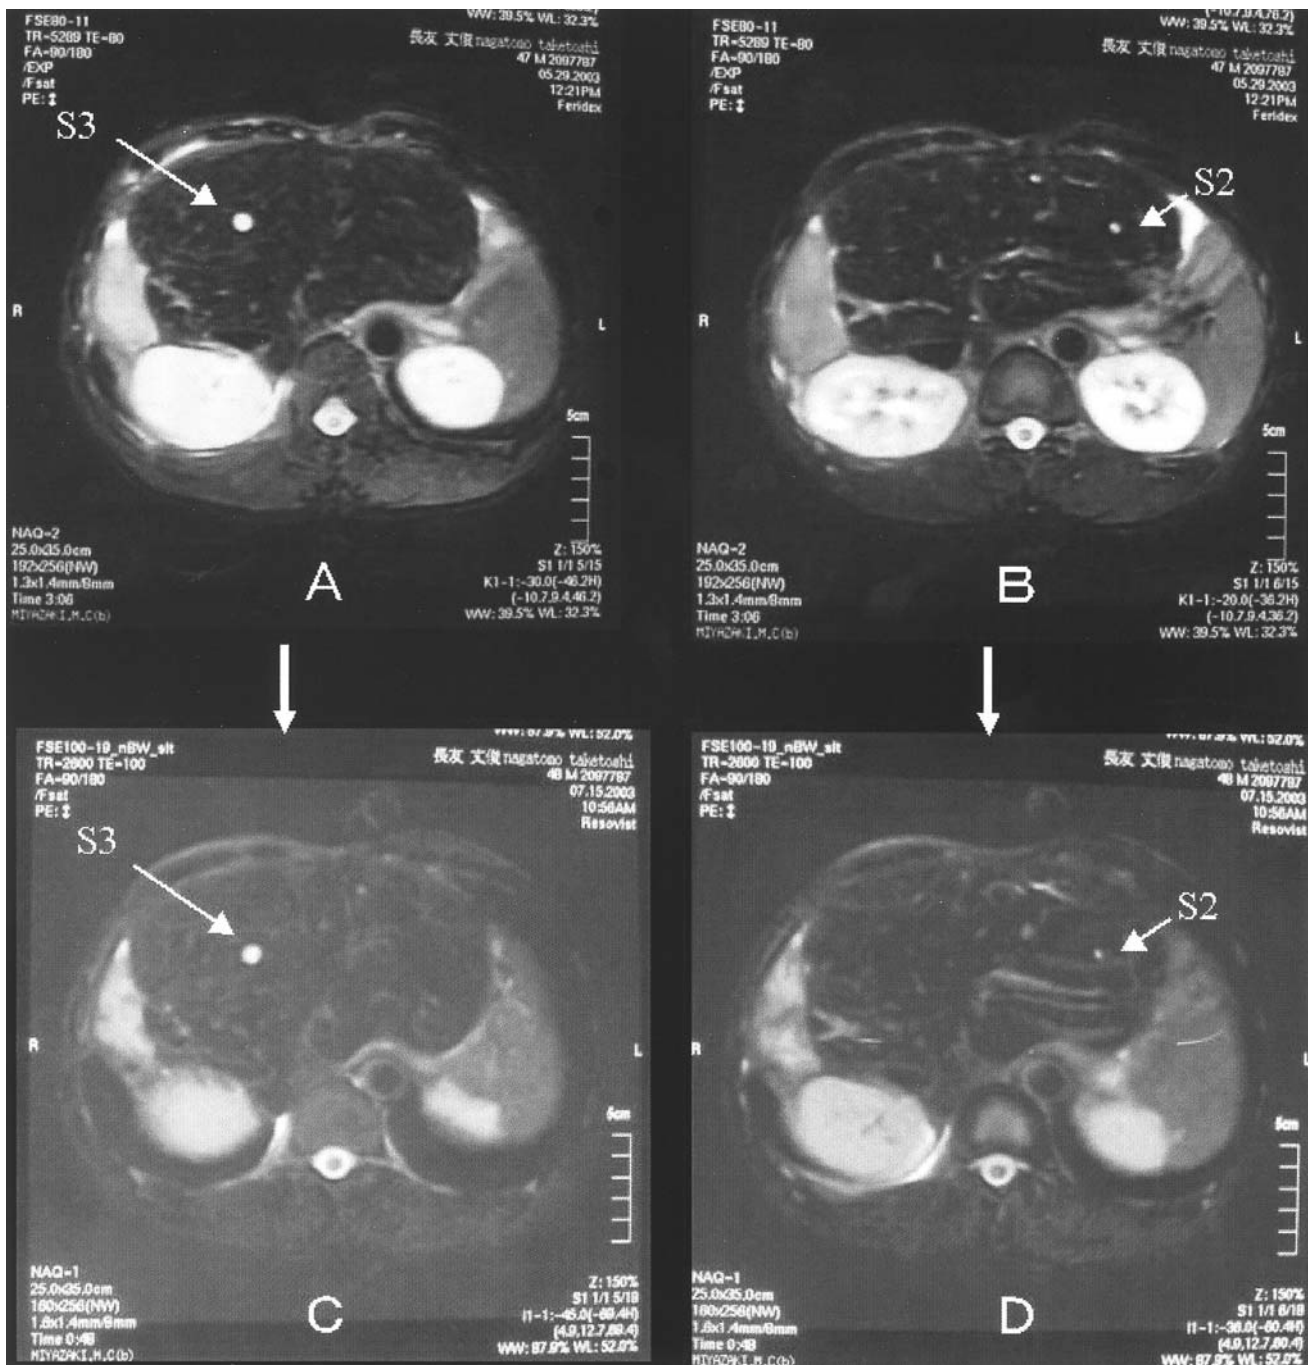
In Case 3, ferridex MRI performed on 29 May 2003 showed two significant lesions, one 1.1cm lesion in the S3 area of liver (A) and one 0.6cm lesion in the S2 area (B). Ferridex MRI, performed on 15 July 2003, showed that both lesions slightly decreased in size (C, D).
